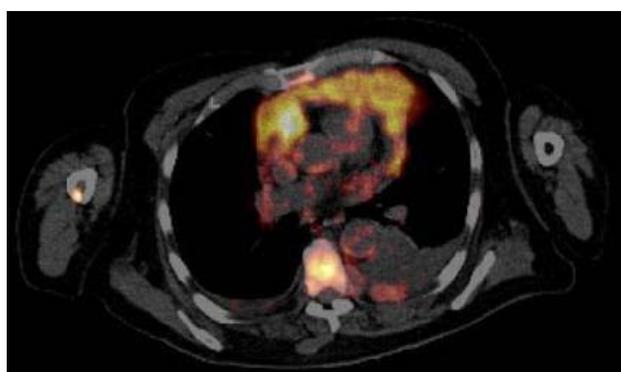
FDG-avid pericardial effusion on PET-CT scan.
